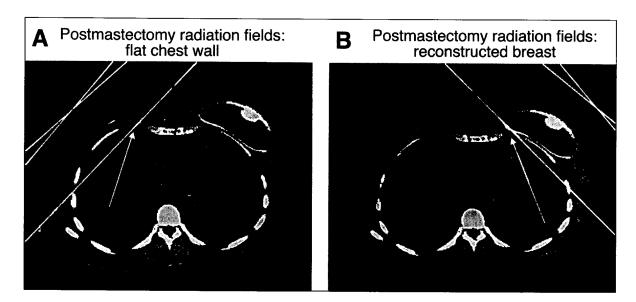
An axial computed tomography slice showing radiation fields used to treat the chest wall after mastectomy (A) or mastectomy with immediate reconstruction using a tissue expander (B). The medial gray fields represent an anterior electron beam field that is geometrically matched to the white x-ray fields used to treat the lateral chest wall. The electron beam field has a rapid dose fall-off to minimize dose to the underlying lung. The gray arrows show the orientation of the radiation beams. The white arrows show the triangles of tissue in the medial chest wall that received less radiation dose at the junction of the fields. As shown, this triangle is much bigger when there is a tissue expander.
